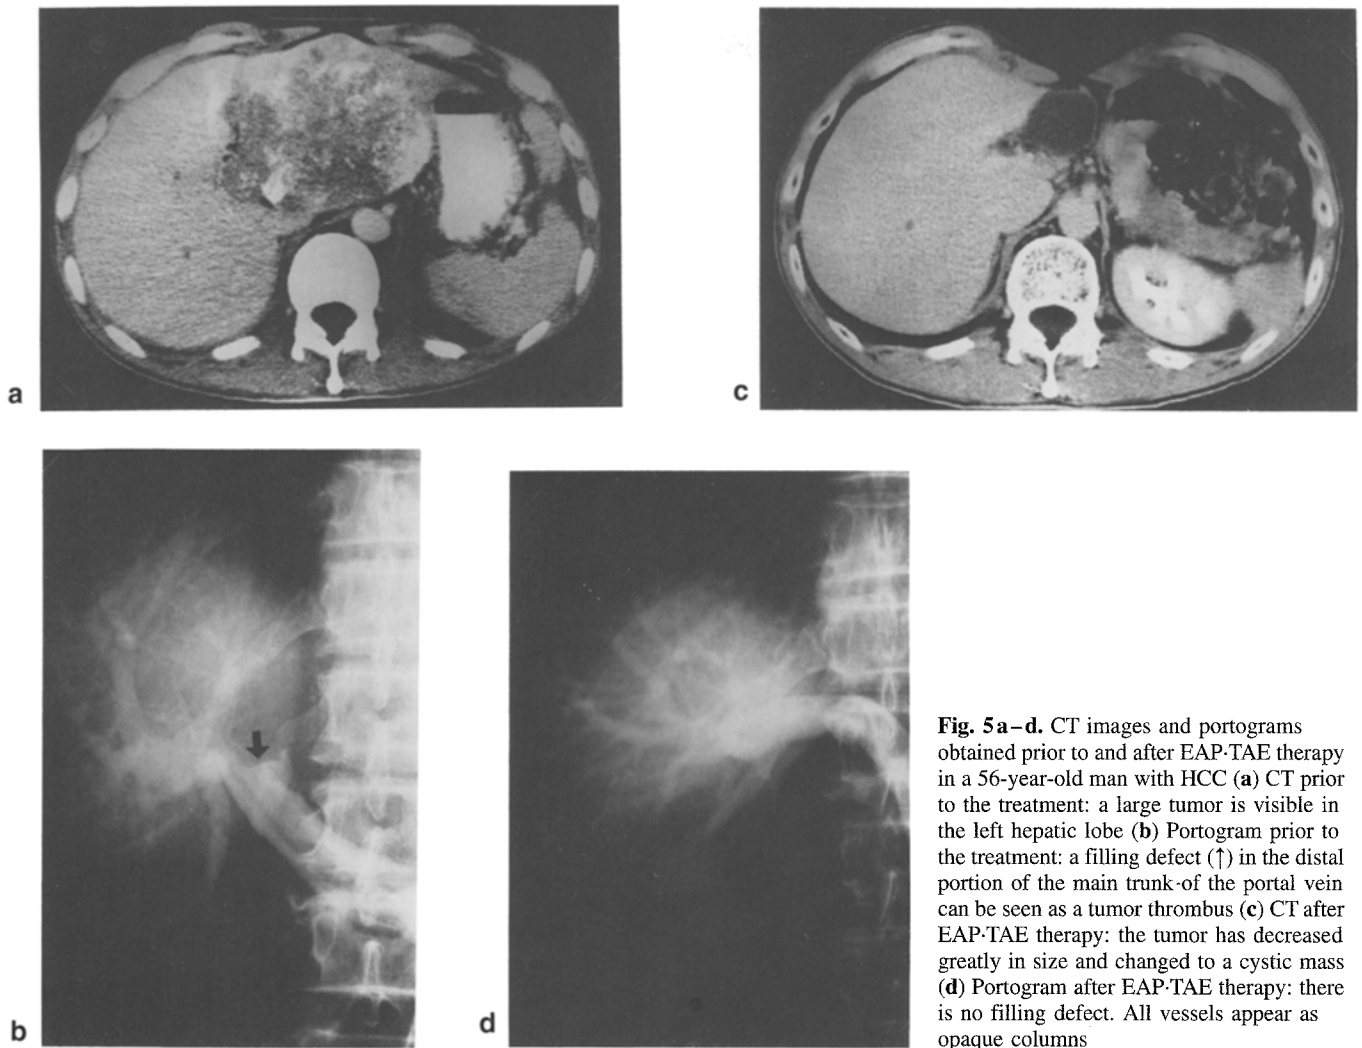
CT images and portograms obtained prior to and after EAP-TAE therapy in a 56-year-old man with HCC (a) CT prior to the treatment: a large tumor is visible in the left hepatic lobe (b) Portogram prior to the treatment: a filling defect (↑) in the distal portion of the main trunk of the portal vein can be seen as a tumor thrombus (c) CT after EAP-TAE therapy: the tumor has decreased greatly in size and changed to a cystic mass (d) Portogram after EAP-TAE therapy: there is no filling defect. All vessels appear as opaque columns
